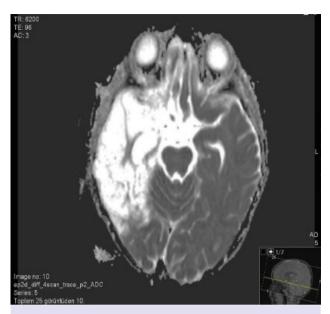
The first cranial magnetic resonance image obtained.
